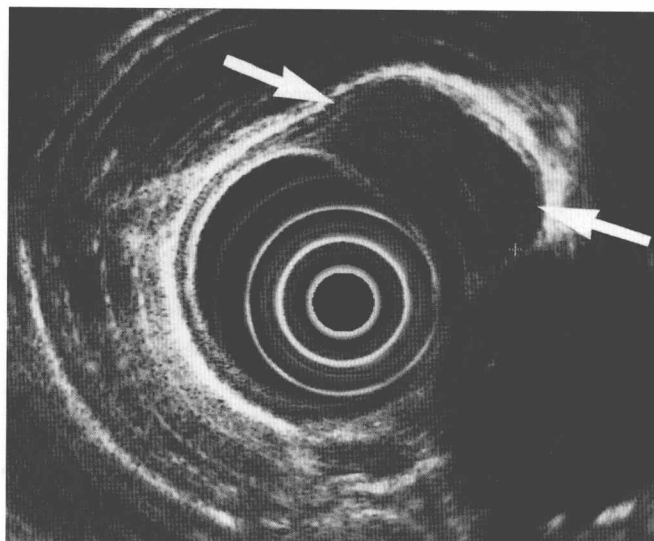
Endoscopic ultrasound of the oesophagus showing a well-defined mass arising in the muscle wall (arrows), suggesting a leiomyoma.
